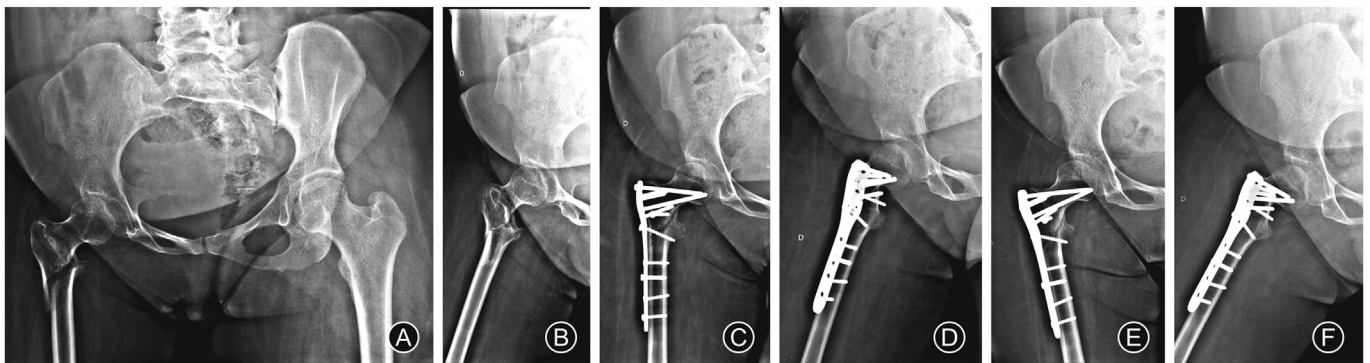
Case 2: a subtrochanteric fracture in a 37-year-old post-polio patient who underwent fracture fixation with a proximal humeral locking plate. (A) and (B): Anteroposterior and lateral views showing the subtrochanteric fracture of the femur in a post-polio patient. (C) and (D): Radiographs in anteroposterior and lateral views showing fracture reduction and fixation with a proximal humeral locking plate (Philos plate, DePuy Synthes®). (E) and (F): Radiographs in anteroposterior and lateral views after 5 months showing fracture healing.
